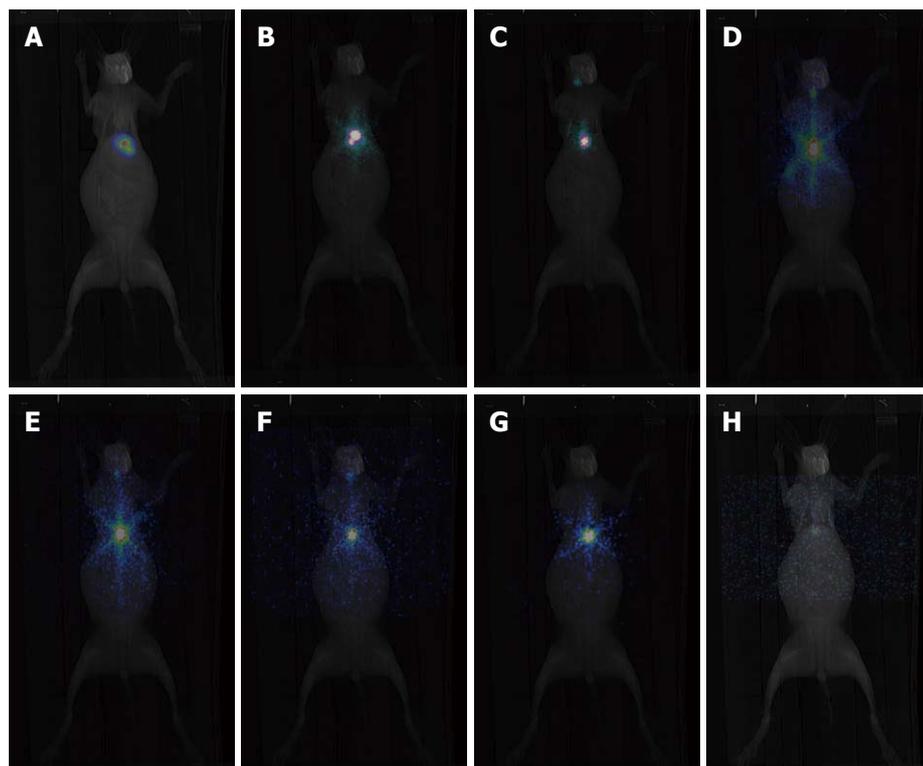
Single-photon emission computed tomography (SPECT) imaging performed at 4 h (A) and 1 (B), 4 (C), 8 (D), 16 (E), 24 (F), 32 (G) and 48 (H) d after the administration of ¹³¹I-labeled gelatin microspheres.
